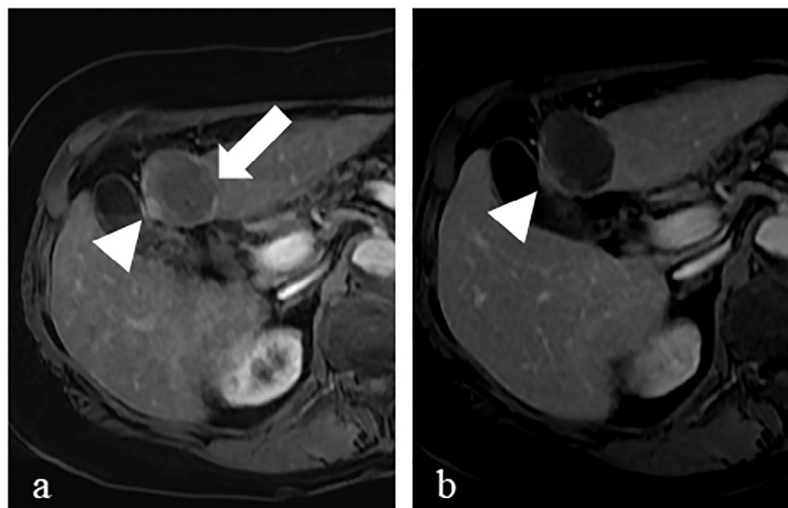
One week after bland coil embolization of the gastroduodenal artery and ethanol ablation of the tumor, magnetic resonance imaging was again performed to monitor for residual tumor viability. (a) Fat saturated T1-weighted post-contrast sequence magnetic resonance imaging shows regression of the larger nodular lesion within the inferomedial treatment cavity (arrow) with persistence of the smaller 1.1 cm lesion (arrowhead) with washout (of the smaller lesion) on (b) delayed fat saturated T1 sequence.
